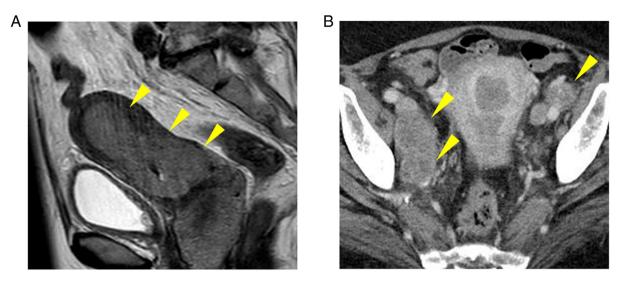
(A) T2-weighed magnetic resonance imaging of the pelvis showed a uterine body tumor (arrowheads) invading the uterine cervix. (B) Computed tomography revealed pelvic lymph node metastases (arrowheads).
